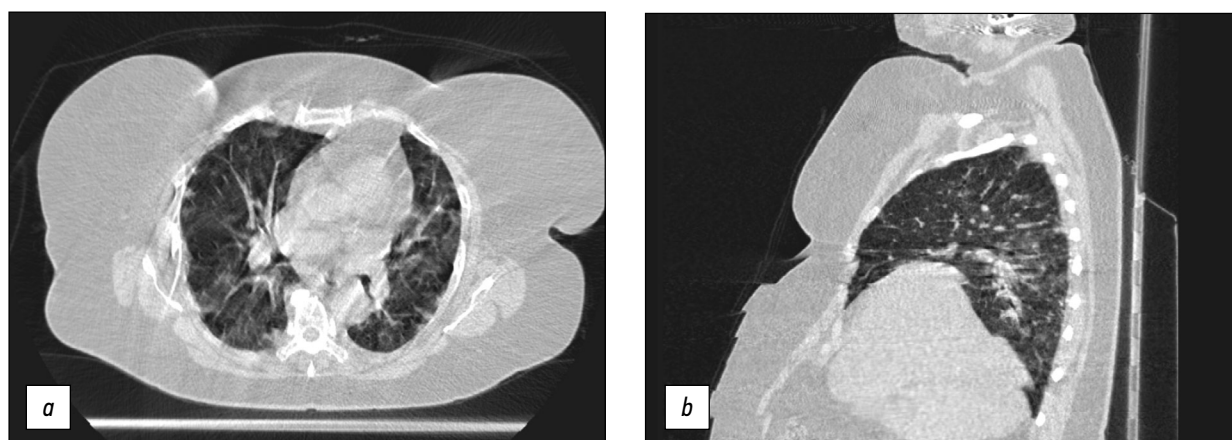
Axial and sagittal computed tomographic slices of chest organs in the lung window: (a) motion artifacts and (b) step artifacts caused by respiratory chest movements during scanning.
